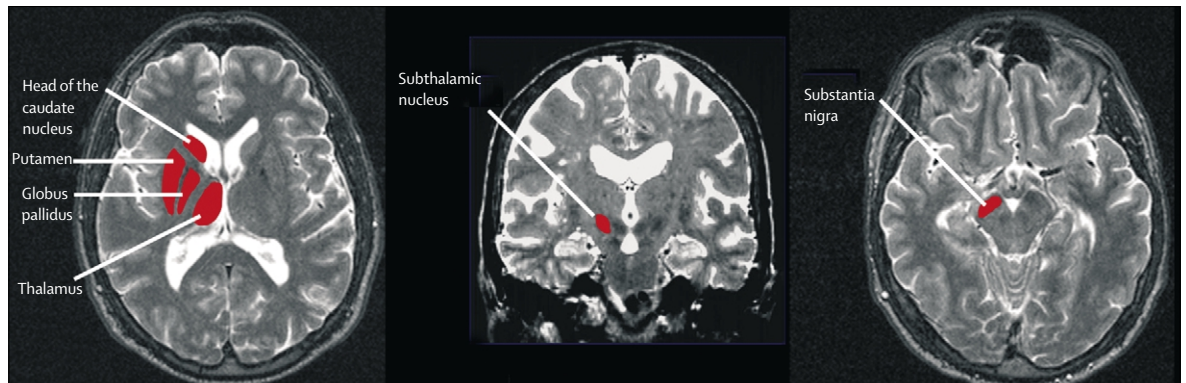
MRI of basal ganglia
